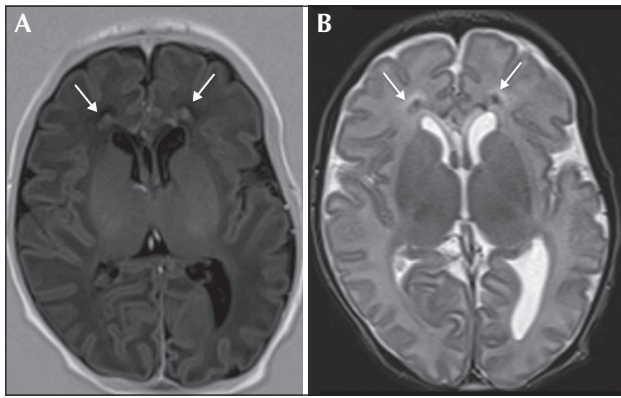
Brain MRI performed at Day 4 of life (Patient 1) showing non-specific white matter lesions in the frontal periventricular region with hypersignal in T1 and hyposignal in T2 weighted images (blue arrow).
